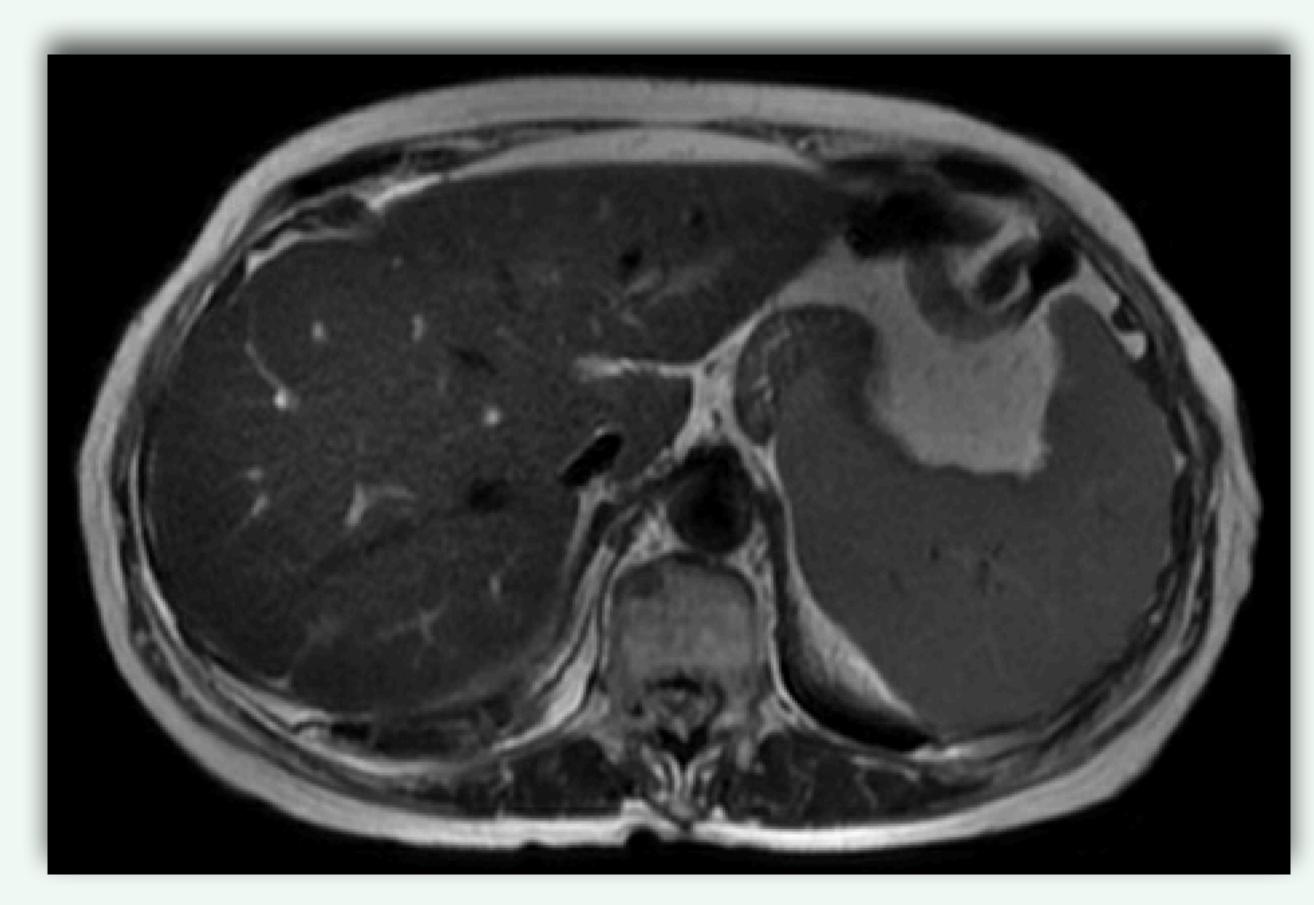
MRI Abdomen showing mild hepatosplenomegaly
